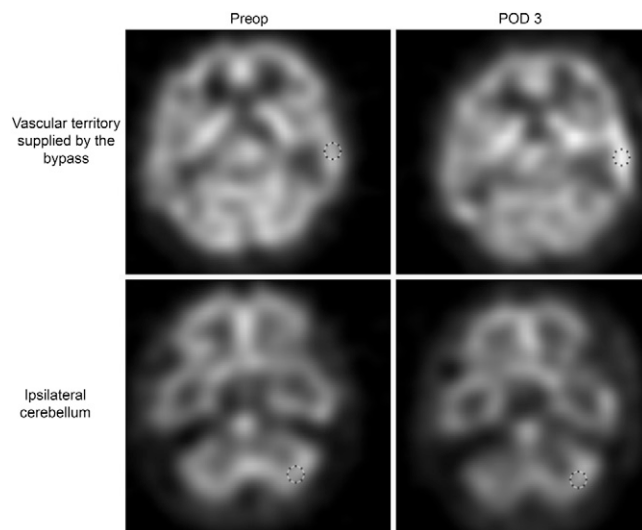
Original SPECT images that were taken preoperatively and 3 days after surgery (POD 3). CBF was quantitatively measured by manually defining a 1-cm diameter ROI in the exact vascular territory supplied by the bypass and the ipsilateral cerebellar hemisphere (dotted circle). For the ROI that was supplied from the bypass, we calculated the radioactivity count divided by that count of the ipsilateral cerebellar ROI. This value was defined as the RCBF. The proportional change in the RCBF (denoted Δ RCBF) within each ROI before surgery and on POD 3 was calculated by dividing the postoperative RCBF by the preoperative RCBF.
